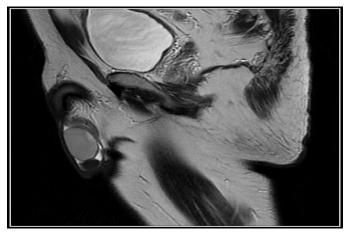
Figure 4, Figure 5: T2W MRI in all 3 planes Axial, sagittal and coronal shows a well-defined T2W hypointense lesion within the left hemiscrotum inferior to the left testis in close relation to the tail of the left epididymis
